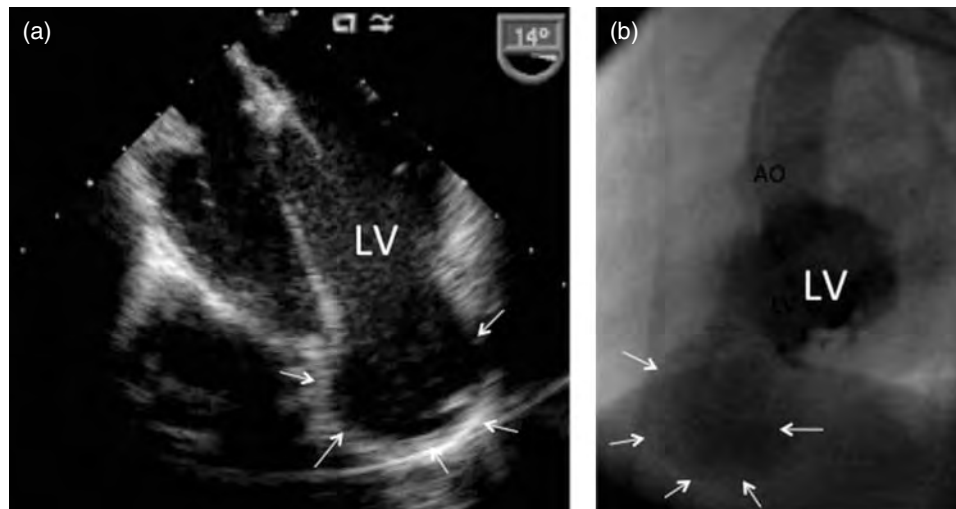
Left ventricular (LV) aneurysm identified in a 4-year-old immunodeficient girl. (Images reproduced from Jamshidi *et al.* 2009 [6]. Reproduced with permission of Elsevier.) (a) The echocardiogram suggested the presence of the aneurysm which was identified extending from the left ventricular apex (arrows). (b) Angiography was performed to exclude a coronary abnormality and further delineate the aneurysm (arrows). This child required surgical resection of the aneurysm after a small mural thrombus was identified.
